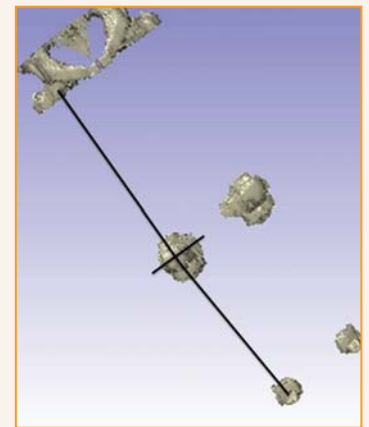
An example of a Pro E model reconstructed from CT scan data to analyze the surgical placement of the implant with respect to the mechanical axes of the femur and tibia as well as analyze placement of the implants in the transverse plane. The data is very useful to input parameters into the computer modeling aspect of the analysis to predict how the total knee functioned.
